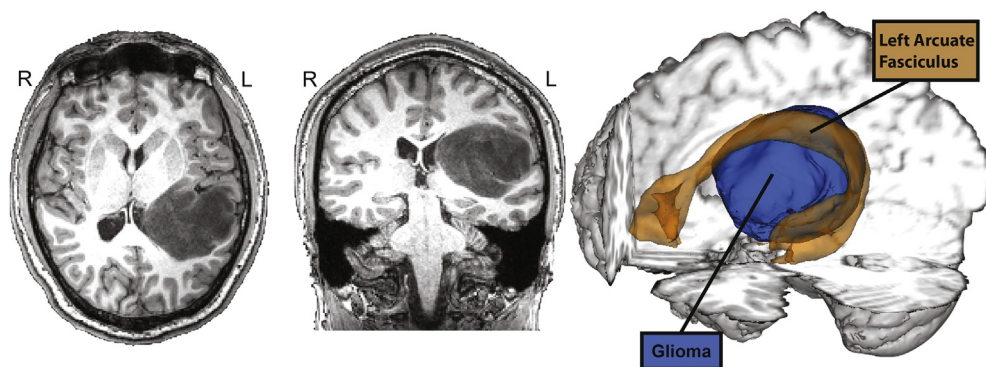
Pre-operative T1 MRI and 3D reconstruction of the left arcuate fasciculus and glioma in patient AH. The arcuate fasciculus is shown in orange at a 5% threshold with the tumor reconstruction in blue.
